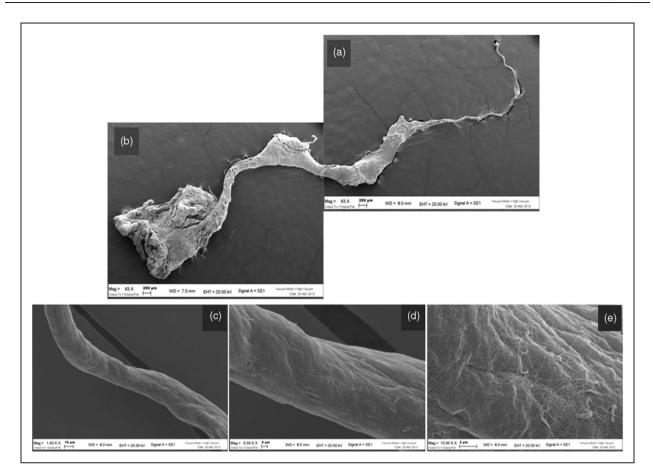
SEM study of a long intraluminal septum, appearing at pre-operative ultrasound as a long and immobile monocusp with no commissure, blocking completely the flow downward the brachiocephalic trunk. (a) Particular of the long free border extended upward till the controlateral wall at $60 \times$. (b) Particular of the wall attachment at $60 \times$. (c–e) At any magnification, $1500 \times$, $5000 \times$, $15,000 \times$ respectively, no endothelial cells are visible. The surface of the intraluminal obstacle appears as a fibrous lamina, with a microreticulate entrapping micro-lipidic spheres.
